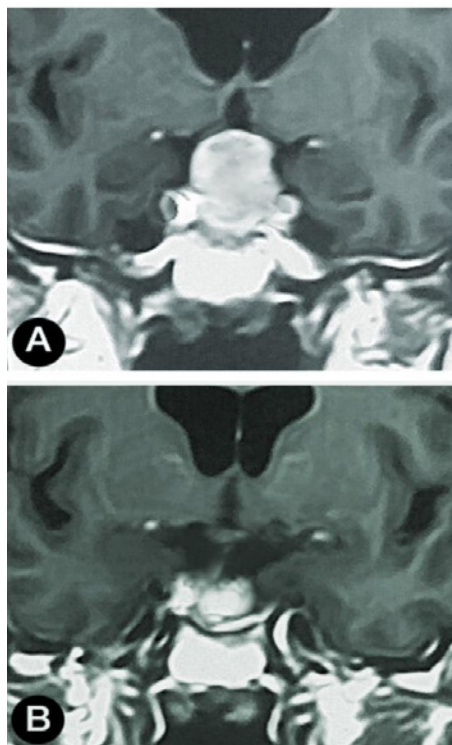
(A) MRI pituitary before treatment showing macroprolactinoma with para – and supra-sellar extension compressing the optic chiasm. (B) MRI of the same pituitary region with significant tumor reduction after 6 months of treatment with QIN (up to 150µg once daily).
